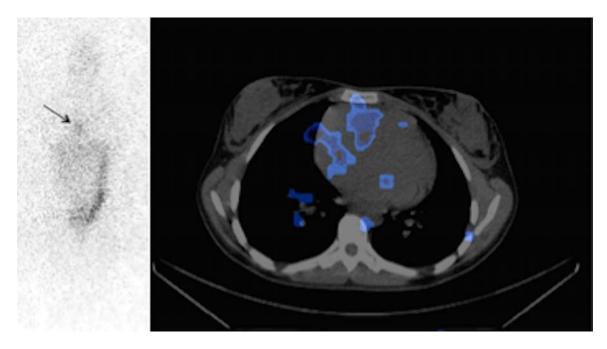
131 Iodine-MIBG anterior planar image, and SPECT/CT showing only mild heterogeneous radiotracer accumulation in the mass.
